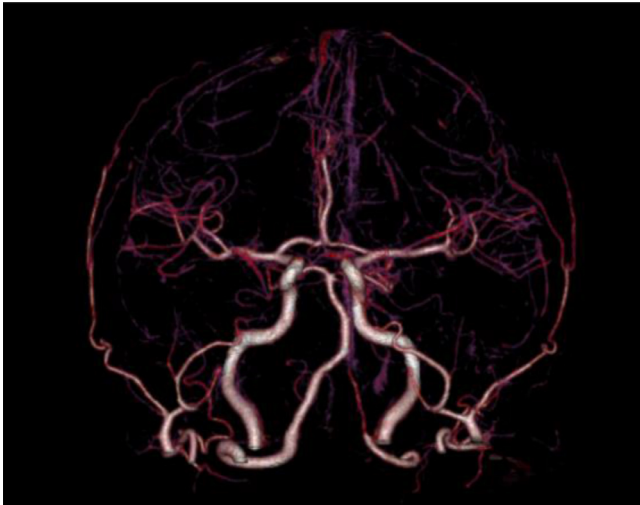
CT angiogram excluded aneurysmal formations.
